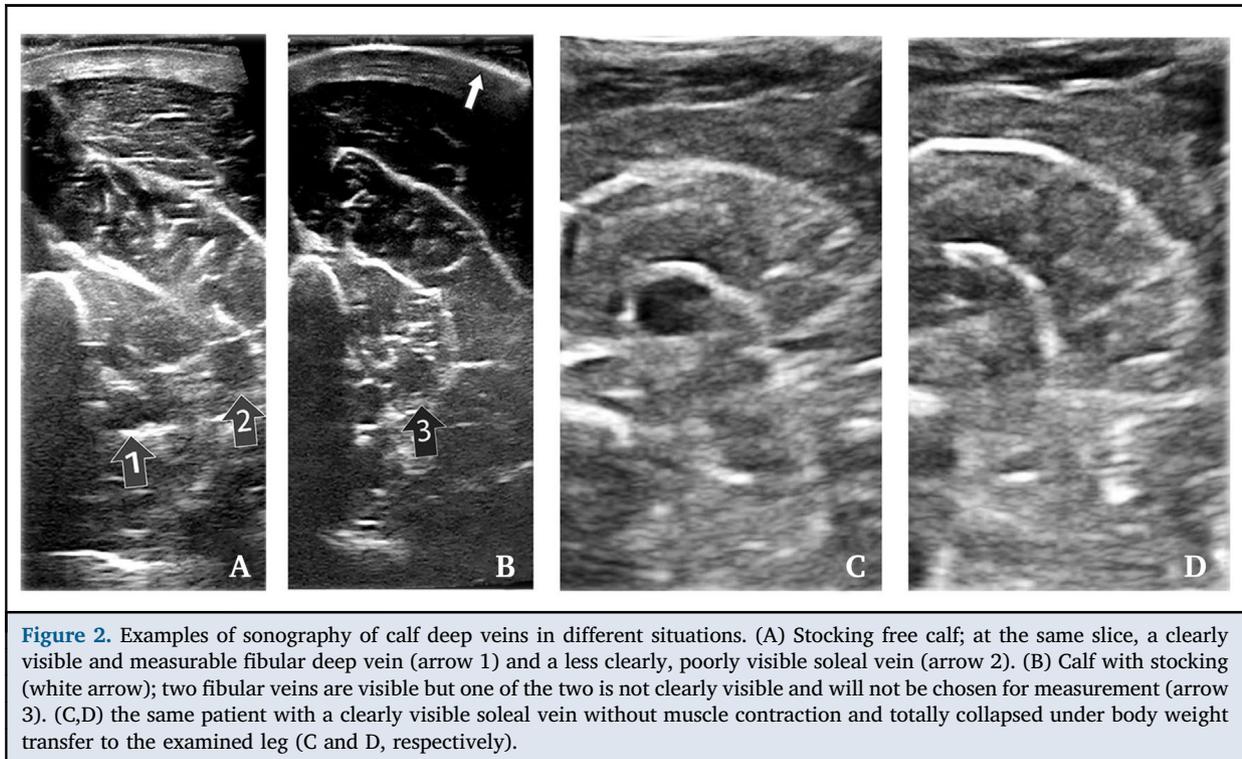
Examples of sonography of calf deep veins in different situations. (A) Stocking free calf; at the same slice, a clearly visible and measurable fibular deep vein (arrow 1) and a less clearly, poorly visible soleal vein (arrow 2). (B) Calf with stocking (white arrow); two fibular veins are visible but one of the two is not clearly visible and will not be chosen for measurement (arrow 3). (C,D) the same patient with a clearly visible soleal vein without muscle contraction and totally collapsed under body weight transfer to the examined leg (C and D, respectively).
